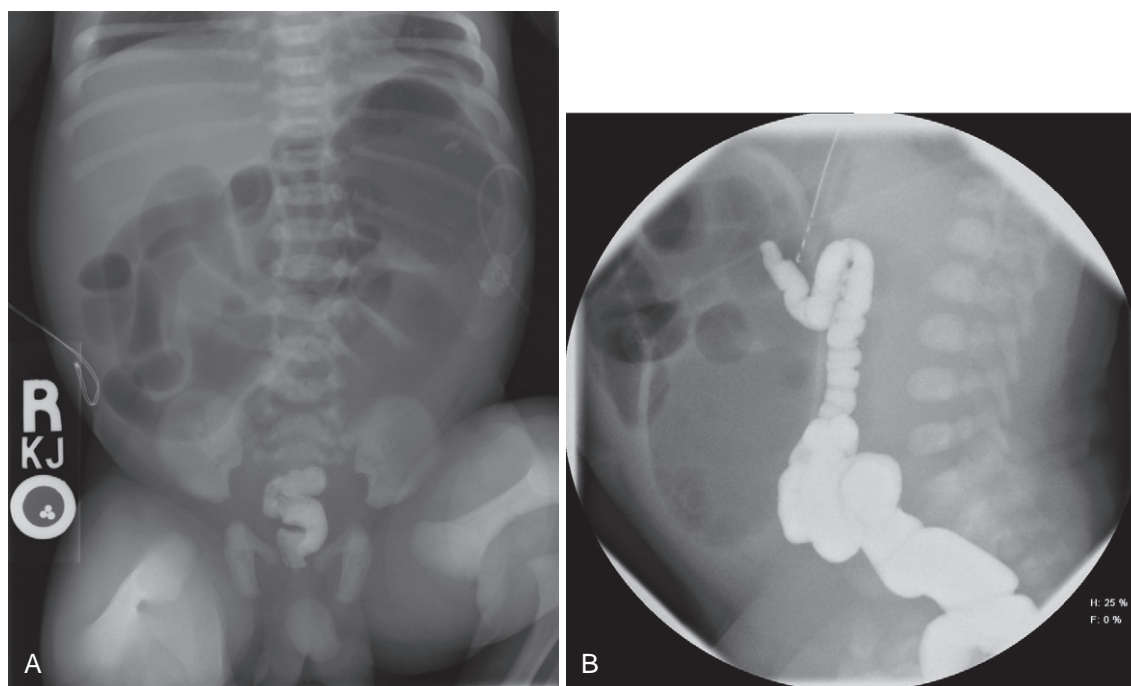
Colonic atresia. A, Plain radiograph of a baby with significant intestinal dilation. Previously injected contrast that was injected per rectum remains in a diminutive rectal segment. B, Contrast enema in the same patient shows a microcolon. On exploration the atresia was at the level of hepatic flexure.
